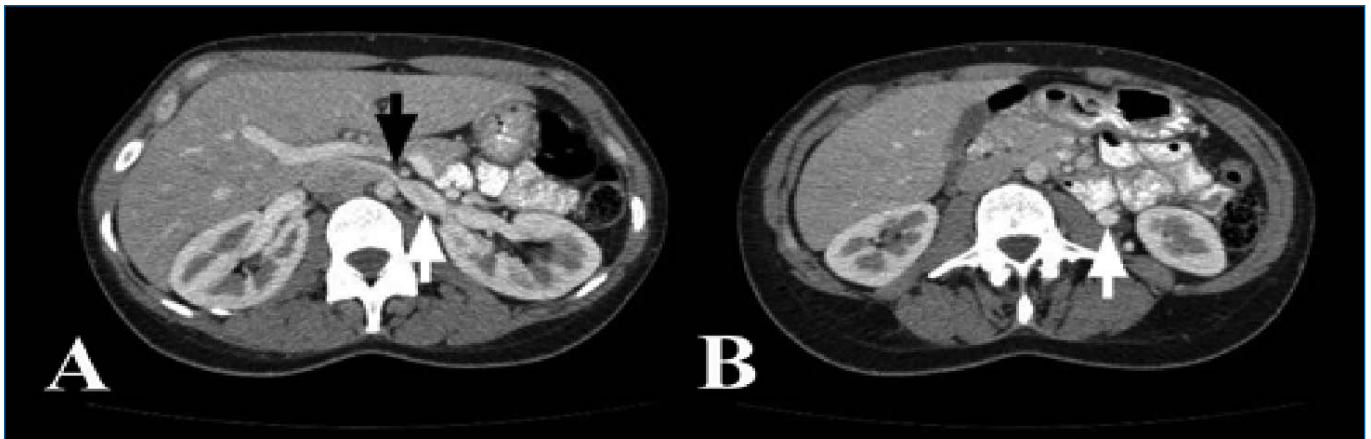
Computed tomography angiogram of a woman with nutcracker syndrome. A: Stenosis of the left renal vein between the superior mesenteric artery and the aorta (black arrow) with proximal dilatation of the left renal vein (white arrow). B: Dilatation and early opacification of the left ovarian vein (white arrow).
